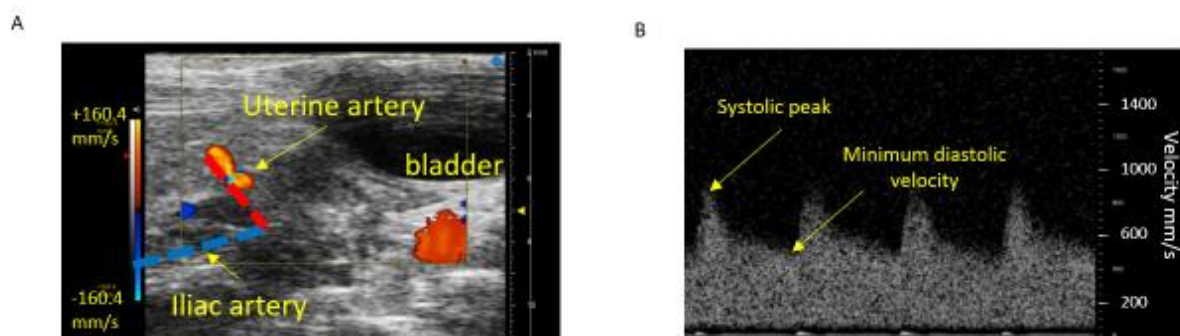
Uterine artery Doppler measurements
